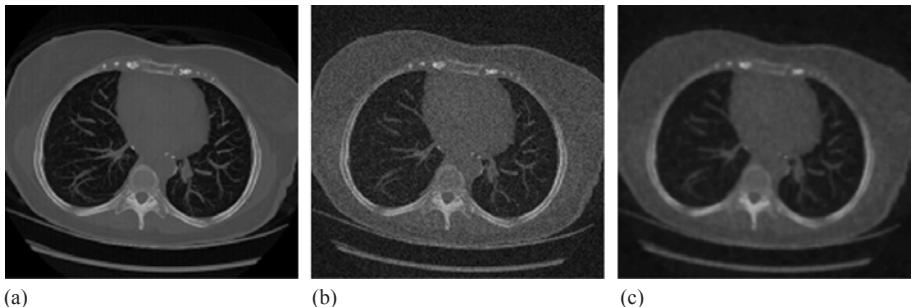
Example of image denoising. (a) Chest CT slice; (b) same slice with added noise; (c) same slice processed with an edge preserving noise removal algorithm. Note that although noise removal eliminates the noise, it also degrades anatomical features (reproduced from the Lung Cancer Alliance Give a Scan database (www.giveascan.org)).
